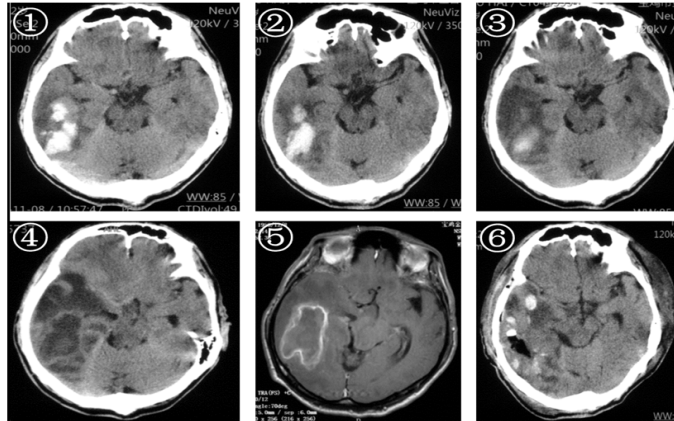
①The CT scan on the 1st day of admission, showing high-density shadow of the right temporal occipital lobe, considering cerebral hemorrhage; ②The CT scan on the 4th day of admission showed that the hematoma volume decreased slightly; ③The CT scan on the 13th day of admission showed that the hematoma was mostly absorbed, with edema around; ④The CT scan on the 36th day of admission showed increased edema, slightly deviated midline, and cerebral herniation; ⑤The contrast-enhanced MRI scan on the 36th day of admission showed a typical ring enhancement at the site of the original hemorrhage; ⑥On the first day after the operation, the head CT scan showed that the lesion disappeared, the midline structure returned to normal.
